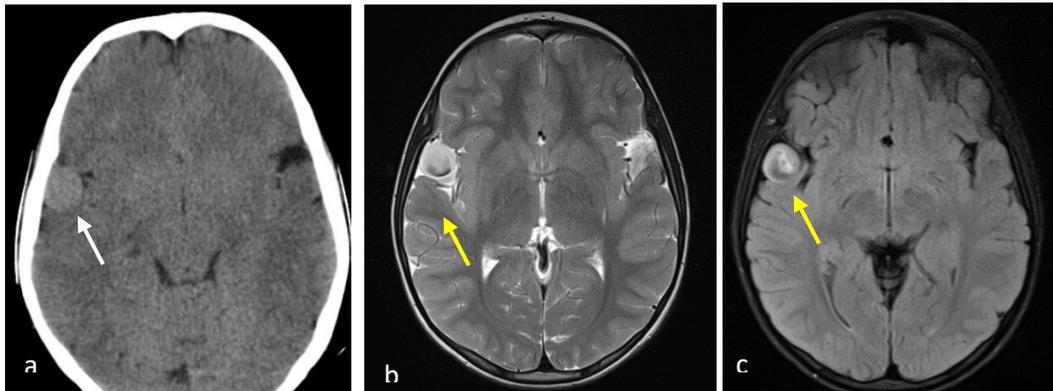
a) axial CT scan showing a round iso to hyperdense lesion in the right sylvian fissure (white arrow); b) first brain MRI showing the lesion hyperintense in axial T2 sequence and c) hyperintense in FLAIR
